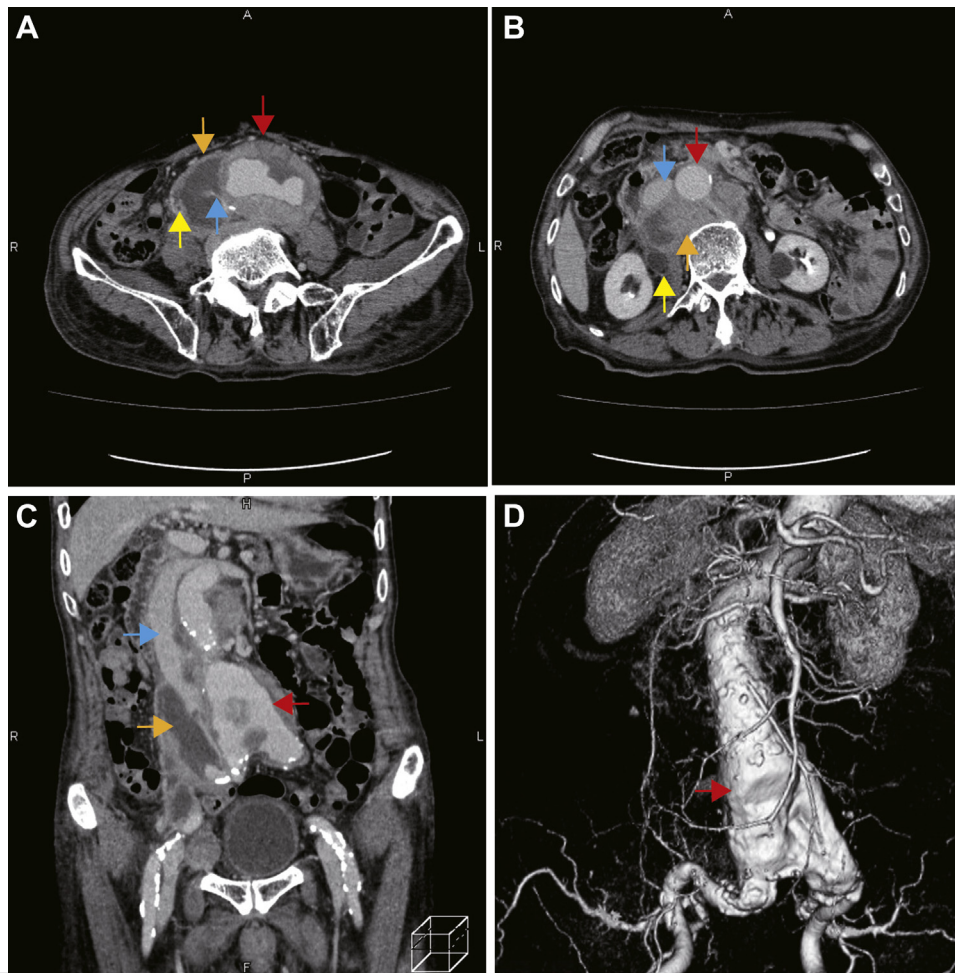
A and B, Delayed enhanced computed tomography (CT) axial images at the levels of the second lumbar vertebra (L2) and L4. C, Coronal view of delayed enhanced CT, showing the periaortic lesion compressing the inferior vena cava and right urinary tract, causing deep venous thrombosis and hydronephrosis. D, Three-dimensional visualization of the abdominal aortic aneurysm (AAA) in a contrast-enhanced CT image. The *red, orange, yellow, and blue arrows* indicate the AAA, periaortic lesion, right urinary tract, and inferior vena cava, respectively.
